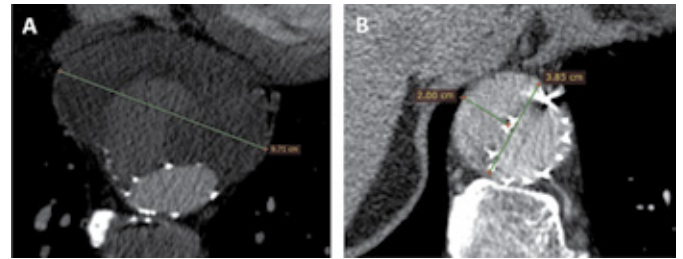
(A) CTA 1 year post-TEVAR revealing a type 1b endoleak and a thoracic aneurysm of 9.7 cm in diameter. (B) The diameter of the false lumen at the level of the supraceliac aorta was 3.8 x 2 cm.
